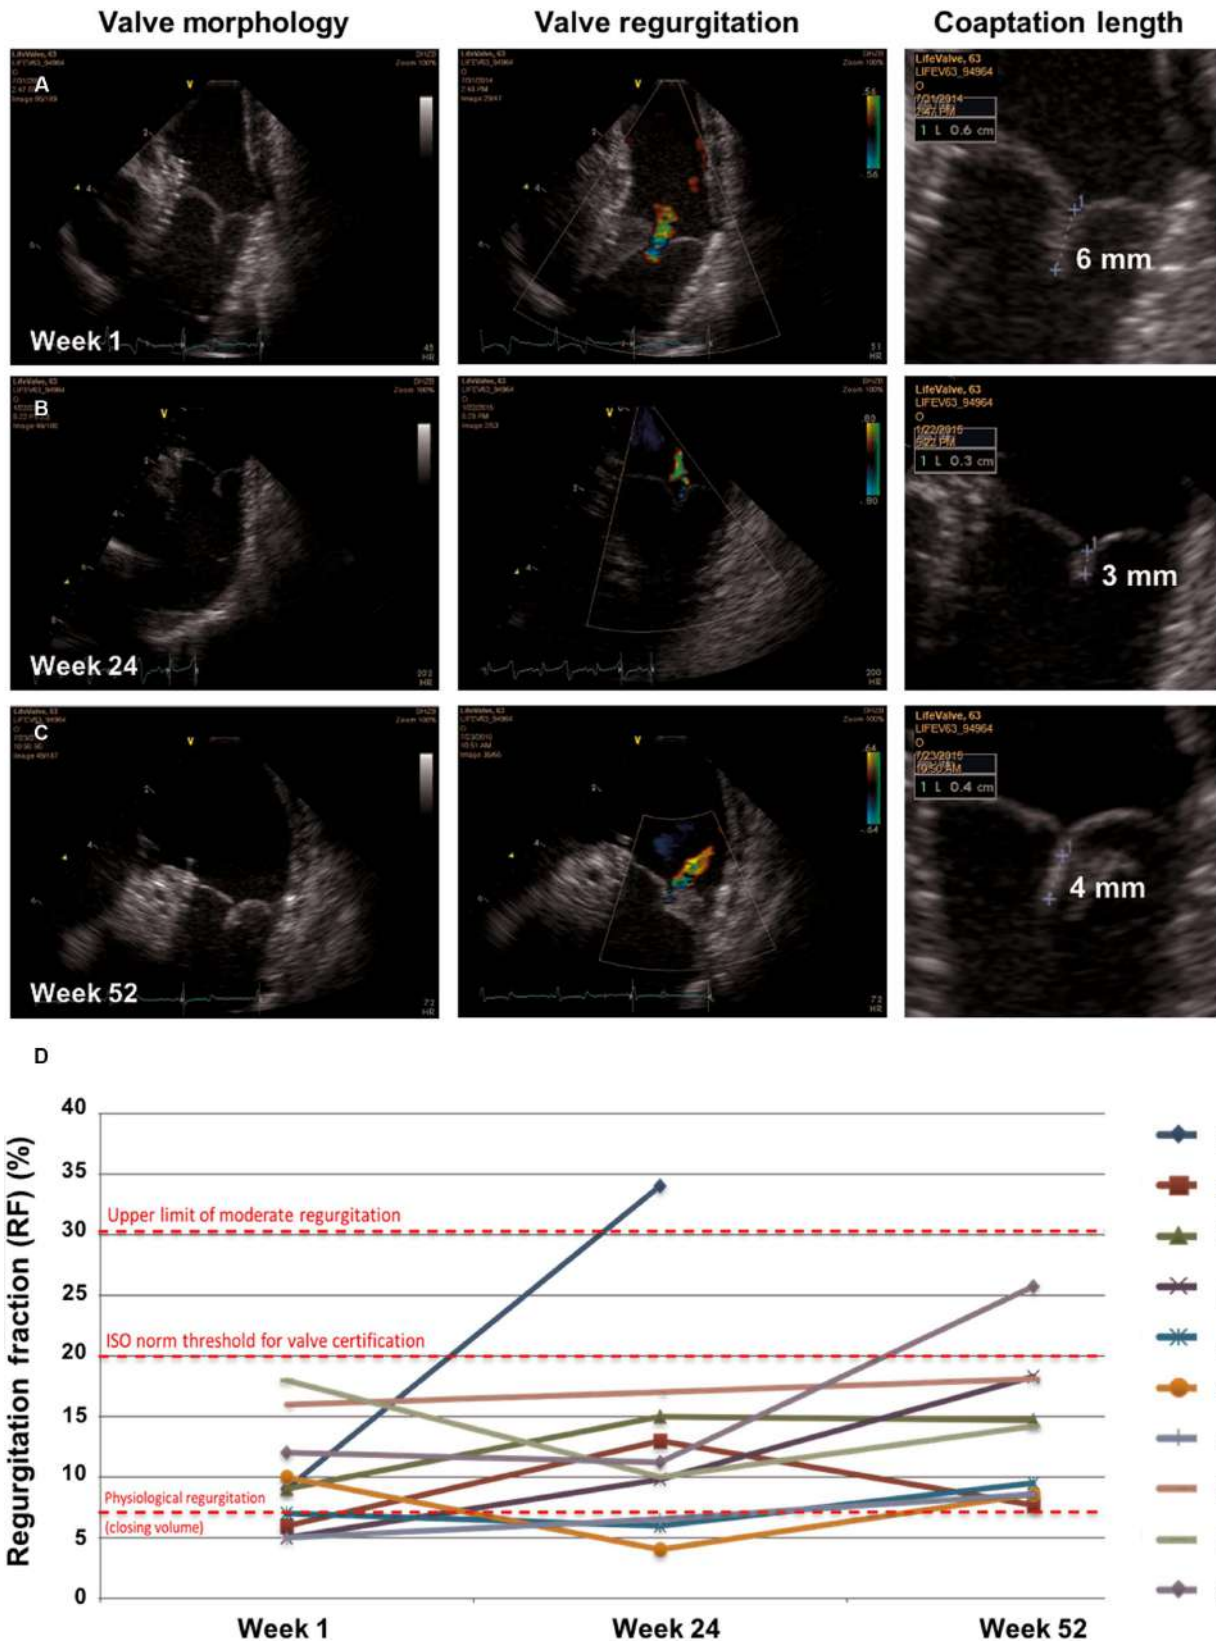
Preserved long-term functionality of the TEHVs over 1-year follow-up as assessed by ICE and cardiac MRI flow measurements. (A to C) ICE evaluation on valve morphology, insufficiency grade (regurgitation), and leaflet coaptation. Exemplary imagery of valve I is shown. (D) Longitudinal cardiac MRI flow analysis of valve regurgitation of all valves at weeks 1, 24, and 52 after TEHV implantation (see also fig. S5).
